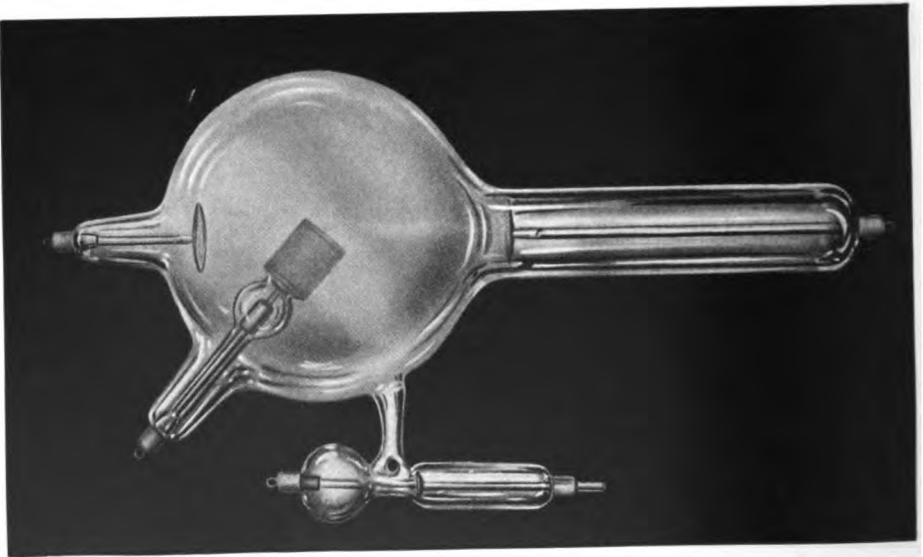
X-ray tube in operation. Vacuum too low.
